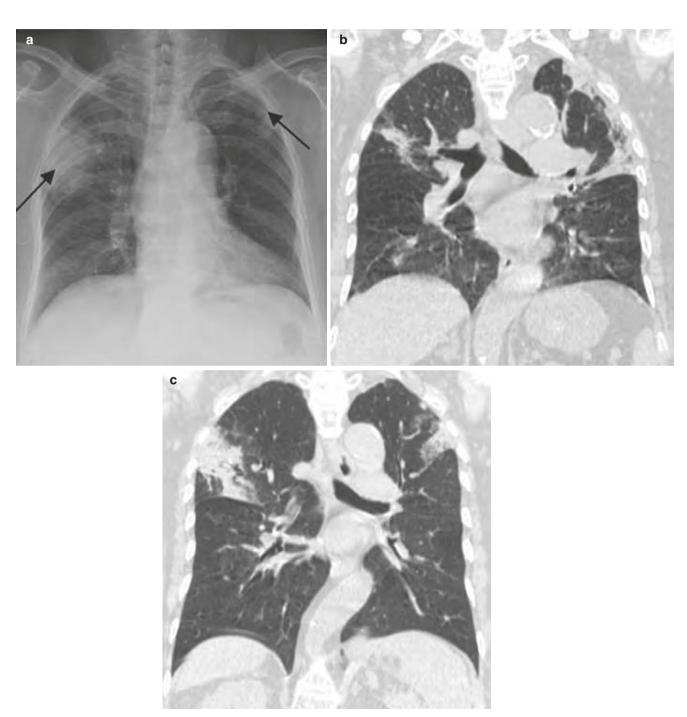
Simple pulmonary eosinophilia. (a and b) Anterior position chest radiograph (a) and CT lung window (b) showed patchy consolidation of upper lobes of both lungs (arrow); (c) 1 week later, reexamination showed the consolidation of the upper lobe of the right lung
